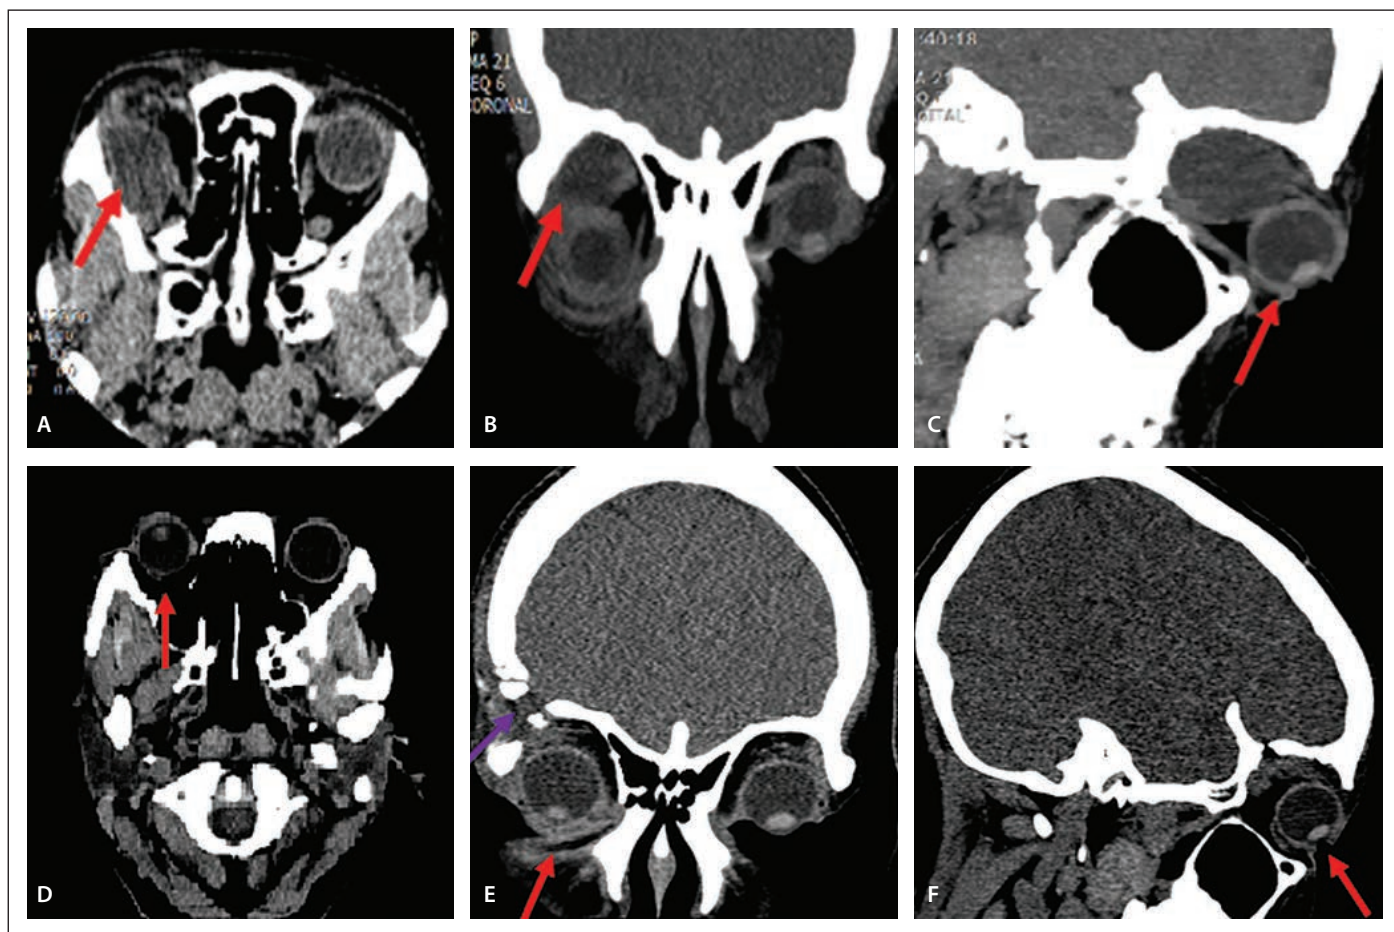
Pre-op optic nerve pushed by the cyst downward and the eyeball inferolaterally in axial (A) and coronal (B) CT scan. (C) Pre-op proptosis in sagittal CT scan. (D) Post-op proptosis resolved in axial CT scan. (E) Post-op proptosis resolved in coronal CT scan, fronto-temporo-orbitozygomatic craniotomy. (F) Post-op proptosis resolved in sagittal CT scan.
